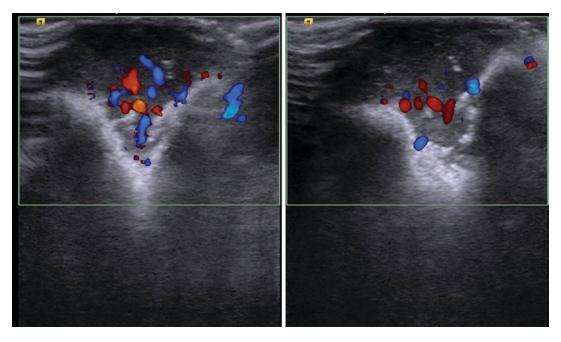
Multiple myeloma. USG image showing heterogeneous hypoechoic lesions with high vascularization on Doppler image
